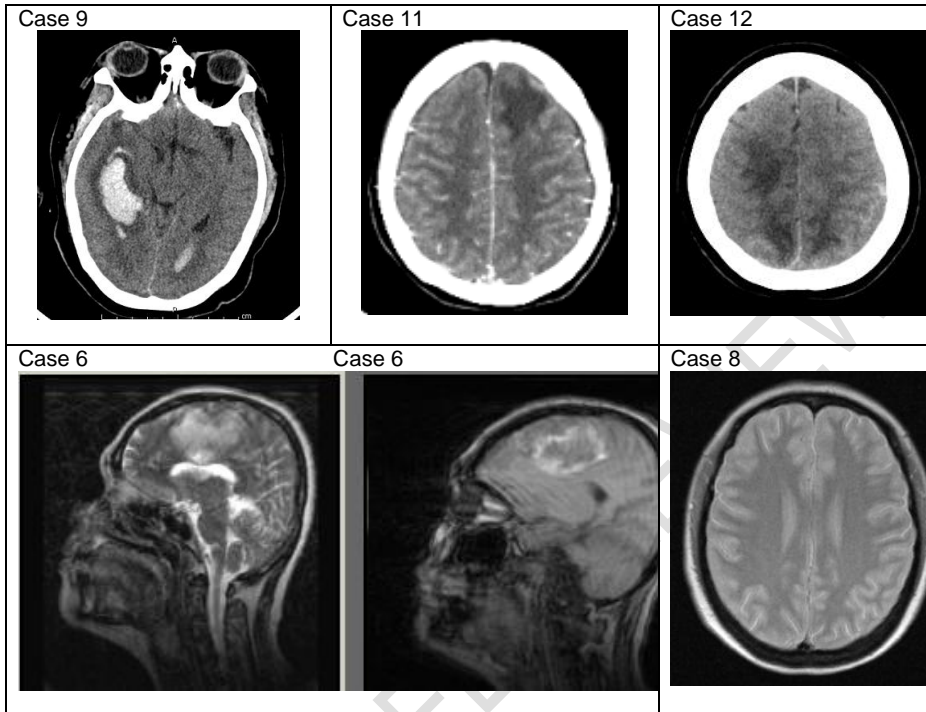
CT and MRI images representative of stroke.
